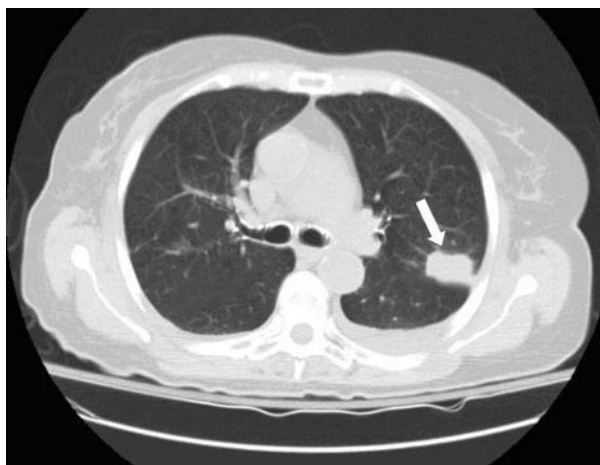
Computed tomography scan demonstrating a dense consolidated left upper lobe lung nodule (arrow).
